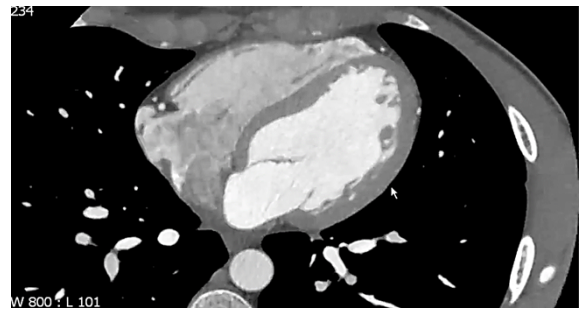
A slice of heart CT-scan image
